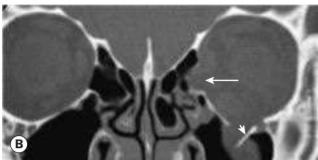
Blow-out fracture of the left medial wall and floor. (A) Defective left abduction; (B) CT coronal view showing fractures of the medial wall (arrow) and floor (arrowhead) (Courtesy of A Pearson)
